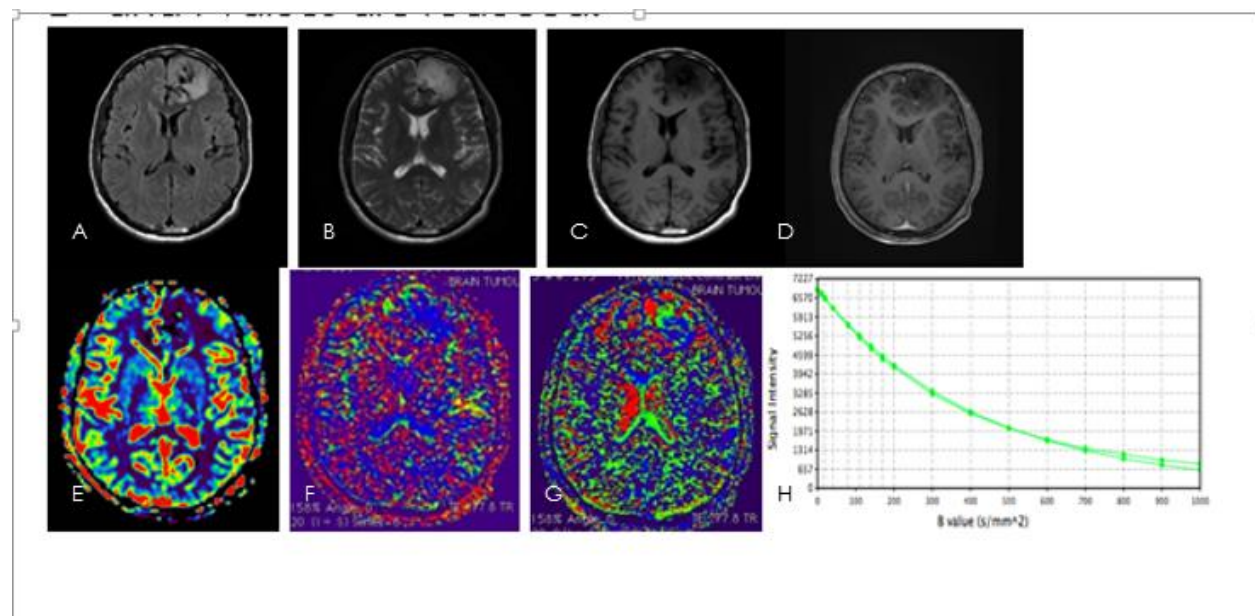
A-C: T2 FLAIR,T2WI,TIWI ,D: Post contrast BRAVO, E :RCBV
